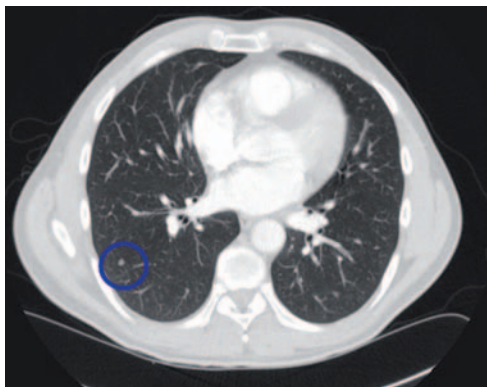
Incidental pulmonary nodule (circled) discovered on staging a new renal cancer. This lesion is too small to classify as a definite metastasis and is too small for PET. A follow-up CT chest was performed at 6 months and 1 year post-surgery, and confirmed an absence of growth of the lesion, which was assumed to be benign.
